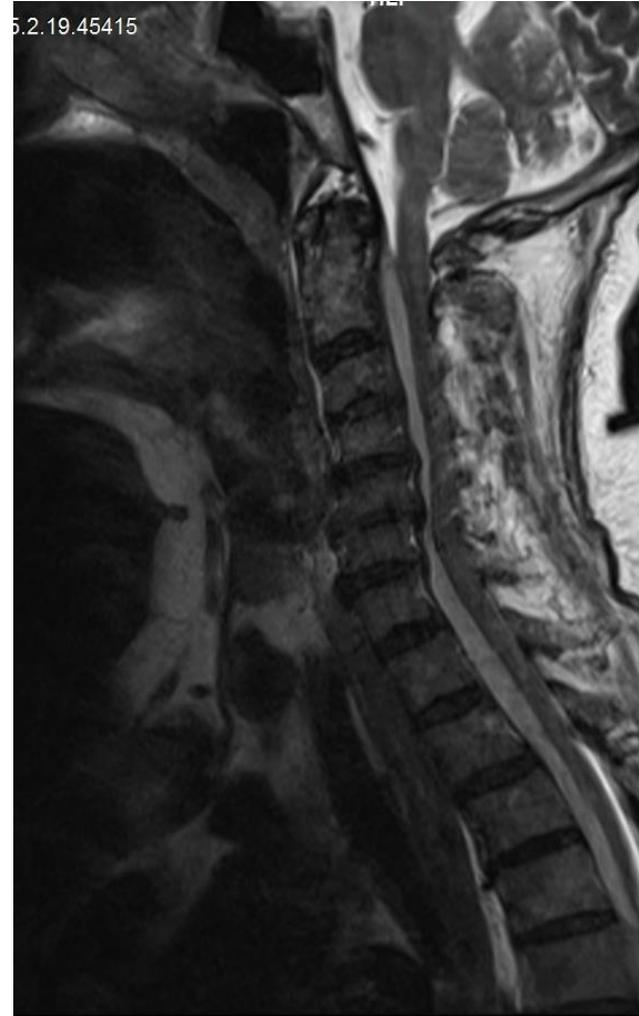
MRI showing spinal tuberculosis associated with TM
